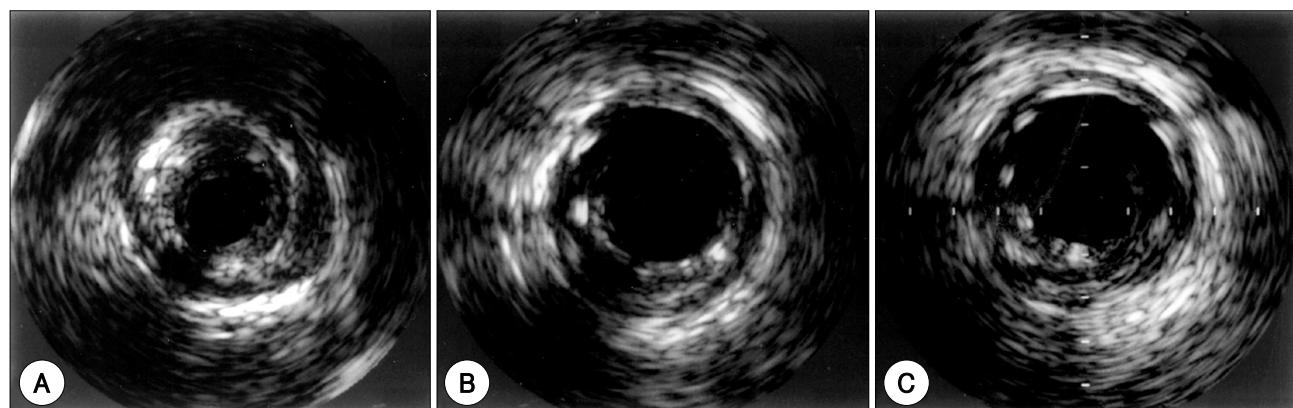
Intravascular ultrasound (IVUS) revealed huge calcified plaques in the middle left anterior descending artery (LAD)(A). Immediately after placing a drug-eluting stent, the stent expanded very well in the middle LAD on the IVUS examination (B). No neointimal hyperplasia was shown on the six-month follow-up IVUS (C).
